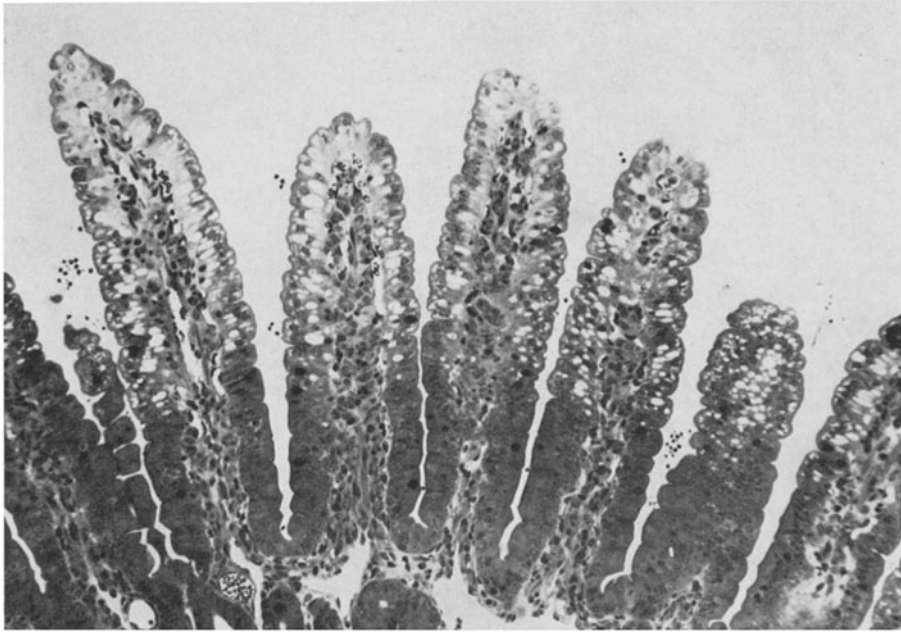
Araldite section of villi, midgut site, 23 hours p.i. The basal portions of the villi are lined by normal columnar cells, while the apical two-thirds are lined by vacuolated cells with rounded margins. Microcrypts are numerous in distal villous margins. Giemsa $\times 140$
